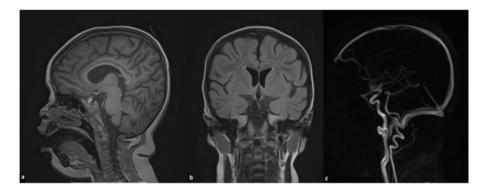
Second brain MRI (2 months after venous thrombosis) - almost complete recanalization of the superior sagittal sinus and disappearance of the parenchymal lesion: a) Sagittal section; b) Coronal section; c) Blood vessel section.
